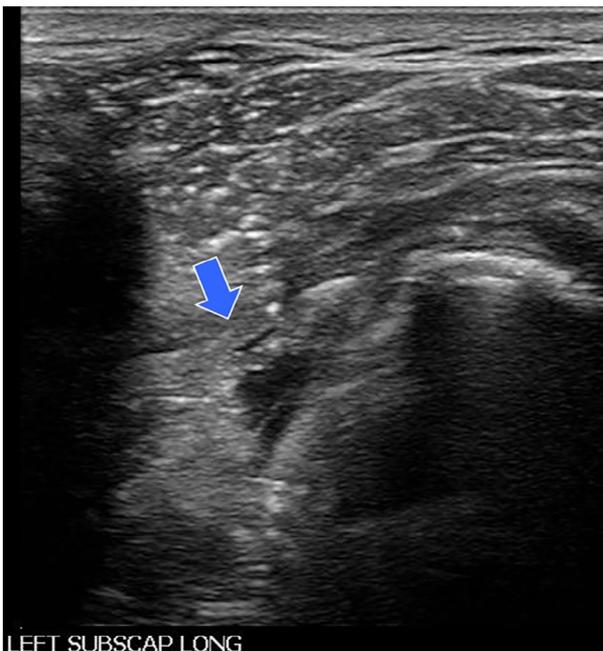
Ultrasound of a failed subscapularis (SUBSCAP), with the arrow pointing to the lesion.
